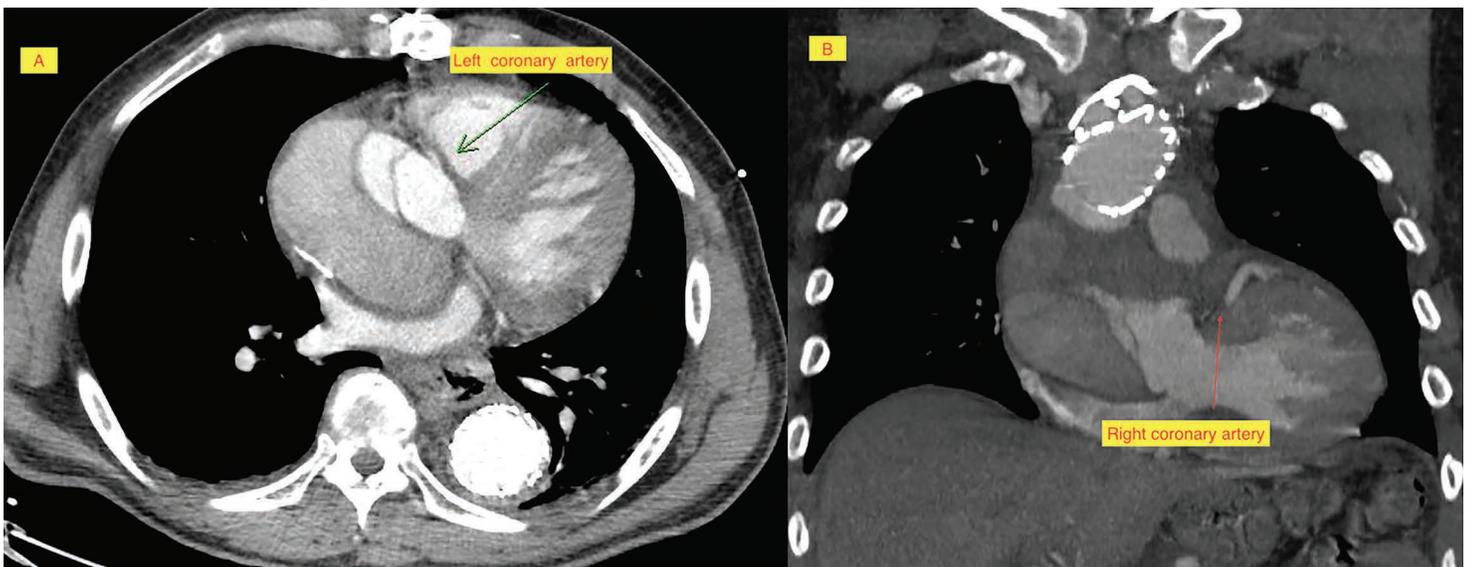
(A) Sagittal computed tomography angiography (CTA) showing the patent right coronary artery. (B) Sagittal CTA showing the patent left coronary artery.
